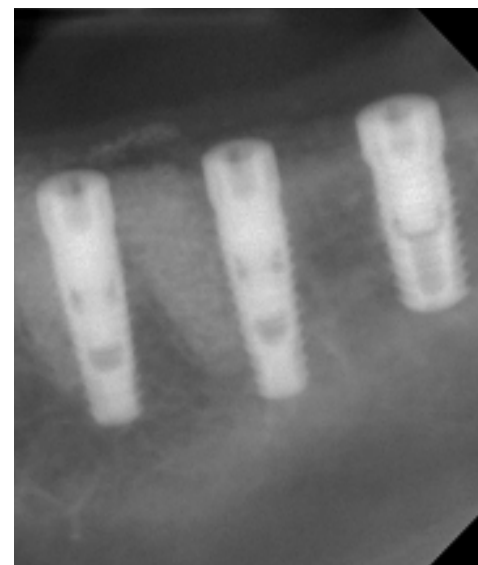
Radiograph of the Camlog implants confirming their position.
